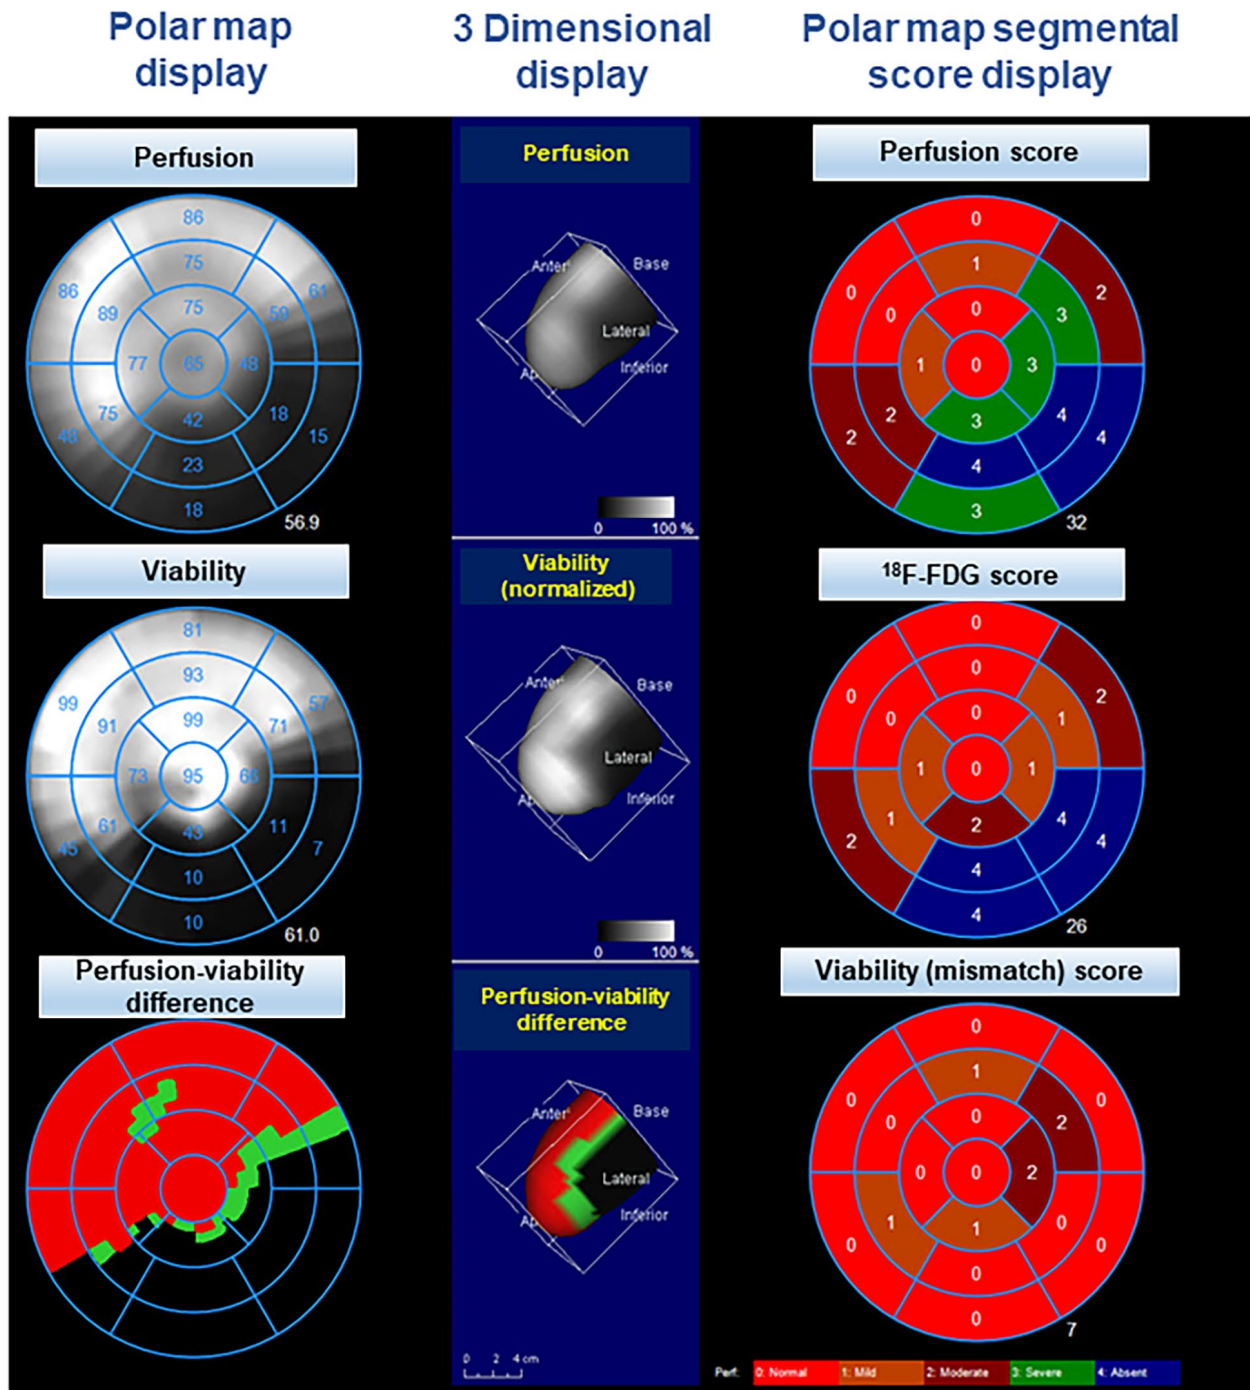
Corresponding to the images shown in Figure 4, the polar map and three-dimensional display of the rest myocardial perfusion SPECT/CT images with ^{99m}Tc-tetrofosmin and ¹⁸F-FDG-PET/CT images in a patient with ischemic cardiomyopathy, demonstrate a predominant “match”.
